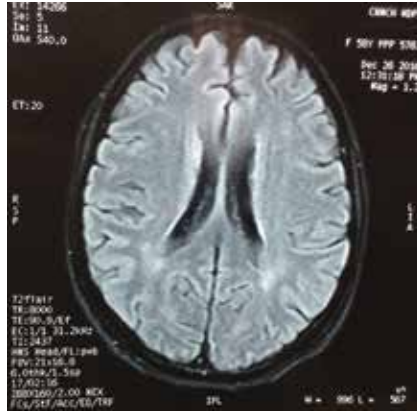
Repeat MRI brain after 2 weeks, showing complete resolution of the hyper intensities
